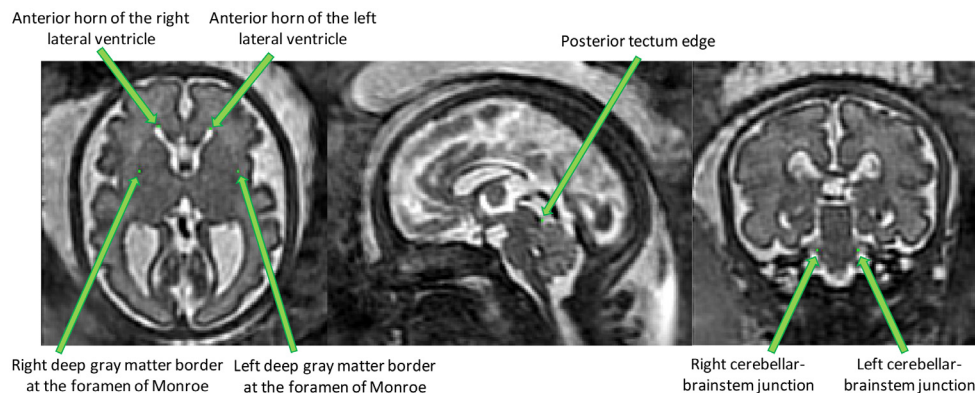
Overview of the proposed anatomical landmarks. Those landmarks were annotated for all the 3D reconstructed magnetic resonance imaging (MRI). They aim at improving the accuracy and the robustness of the image registration steps.
